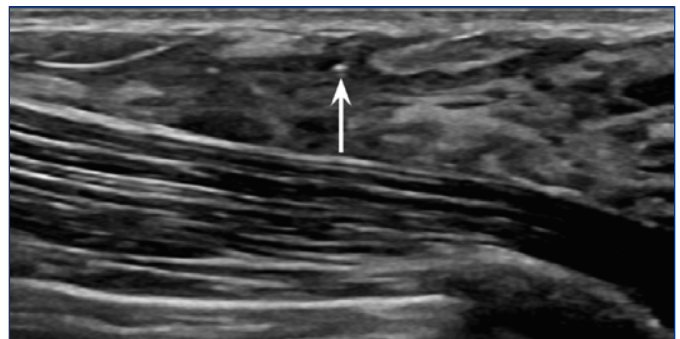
Ultrasound 9 months status post cryoablation demonstrates the echogenic focus of the biopsy mark clip (notched arrow) but no measurable mass.
